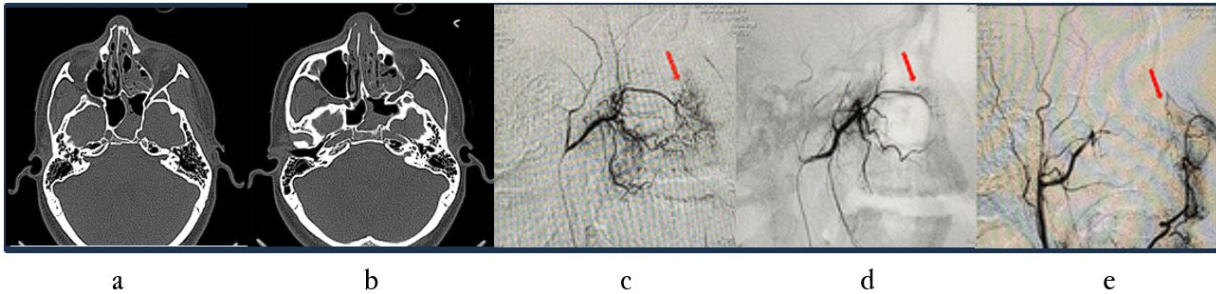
CT scan of the face, which revealed a Le Fort I maxillary fracture, a nasal bone fracture (OPN) and a complex fracture of the zygomatic bone on the right, all with no significant displacement (a,b). Superselective arteriography of the left internal maxillary artery in the lateral projection, showing hypervascularization of the nasosinusal region irrigated by the sphenopalatine and descending palatine arteries (c). Post-embolization angiographic control with PVA (350-550 $\mu$ m) showing irrigation by the descending palatine artery (d). Anastomoses between the internal and external carotid arteries should be excluded before embolization. Postembolization angiographic control with PVA (350-550 $\mu$ m) of the sphenopalatine artery (e,f).
